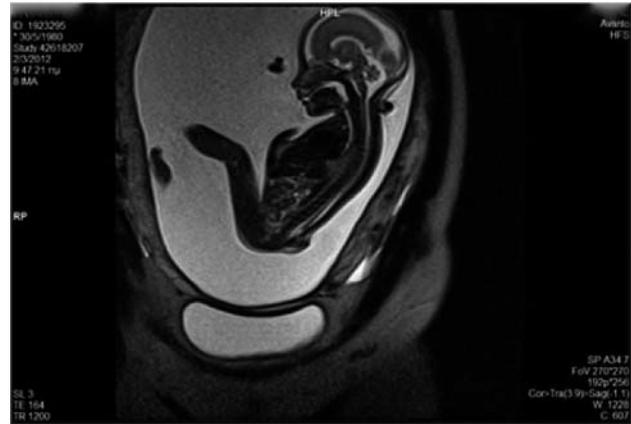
A more detailed image of the lesion by MRI. The lipoma extends to the spinal cord, tethering the cauda equina.
